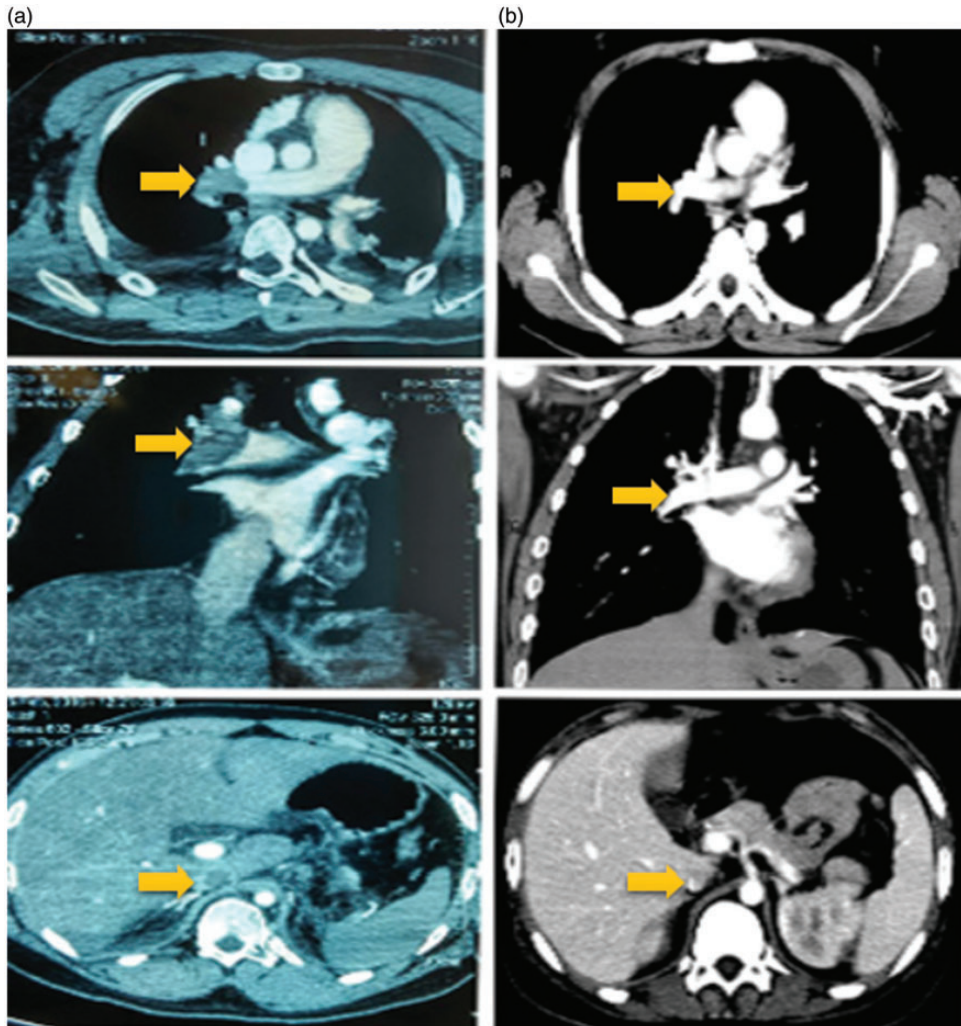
Chest and abdominal computed tomography showing (from top to bottom) chest axial, chest coronal, and abdomen axial views. (a) Views on admission to our hospital. These views suggested multiple embolisms in the bilateral pulmonary artery, upper and lower pulmonary artery trunk, and branches of blood vessels as well as in the inferior vena cava near the liver section thrombosis. (b) Views at discharge. These views indicated residual thrombi in the left pulmonary artery trunk and in the basal segments of the lower lobe of the left lung and inferior vena cava near the liver-filling defect. Differences in the thrombus before and after treatment are indicated using arrows.
